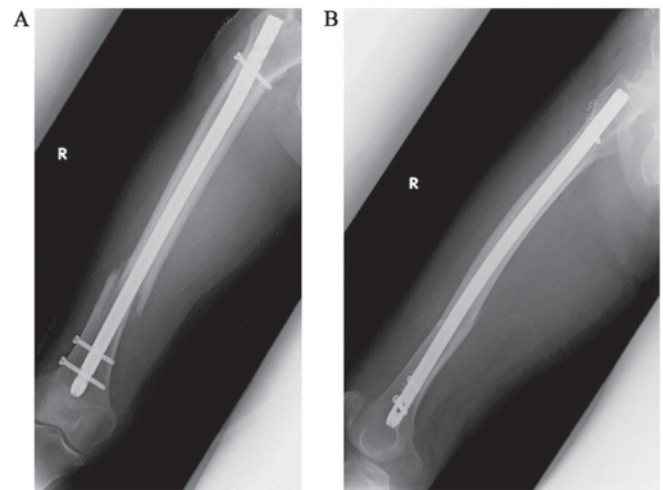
Postoperative radiographs. Plain radiographs of the right femur following the initial surgery. (A) Front view. (B) Side view.
